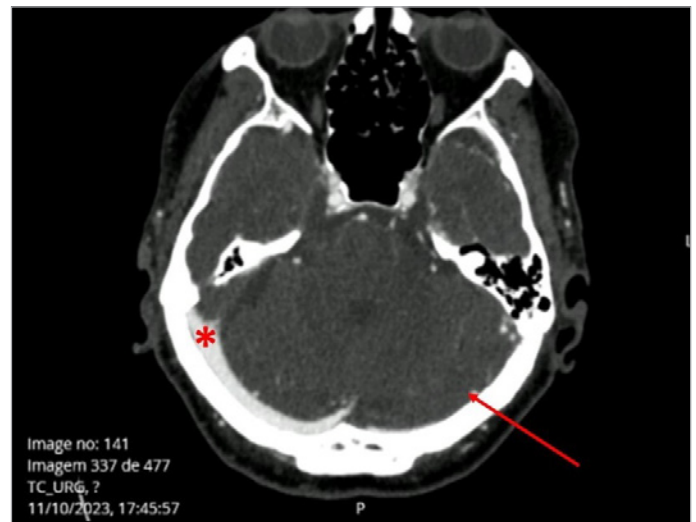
Complementary Diagnosis Exams - Venous - Brain CT
